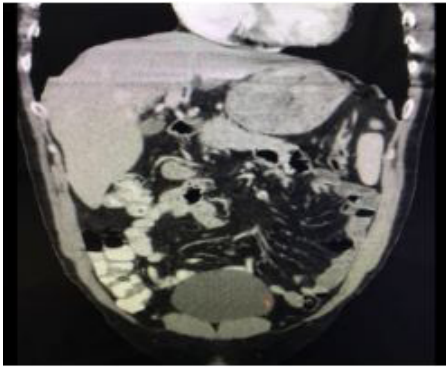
Abdominal CT that Shows the Gastric Mass. Coronal Section.
